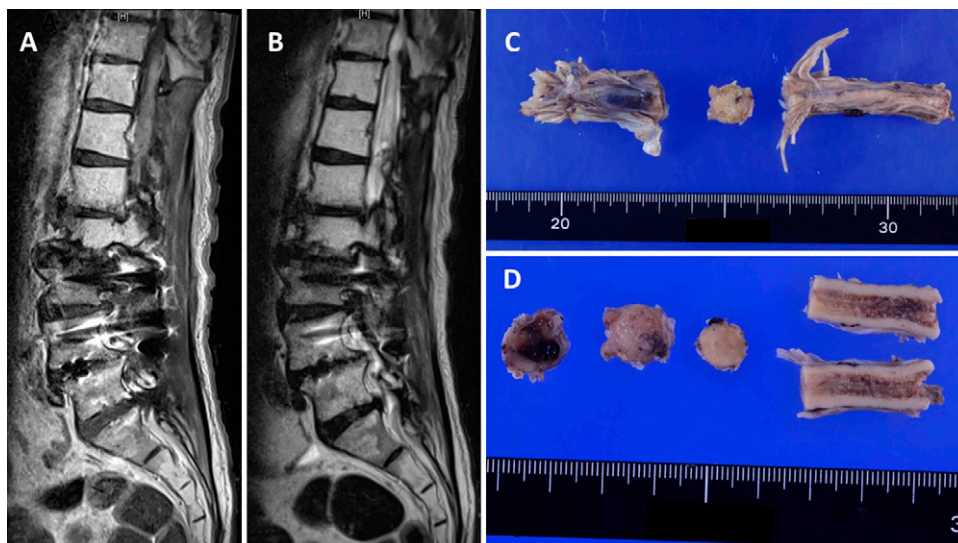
Enhanced T1-weighted image revealed an intramedullary, heterogeneously enhanced lesion extending from T10 to L2 a year after the initial surgery (A). A T2-weighted image showed an enlarged edematous spinal cord (B). The patient underwent lower thoracic laminectomy and corpectomy below T9. The transected spinal cord was submitted for pathological evaluation (C). The affected spinal cord was enlarged and partially necrotic with hemorrhagic components. Cross-sectioning revealed infiltration of the tumor and the resultant destruction of the boundaries between white matter and gray matter of the spinal cord (D).
